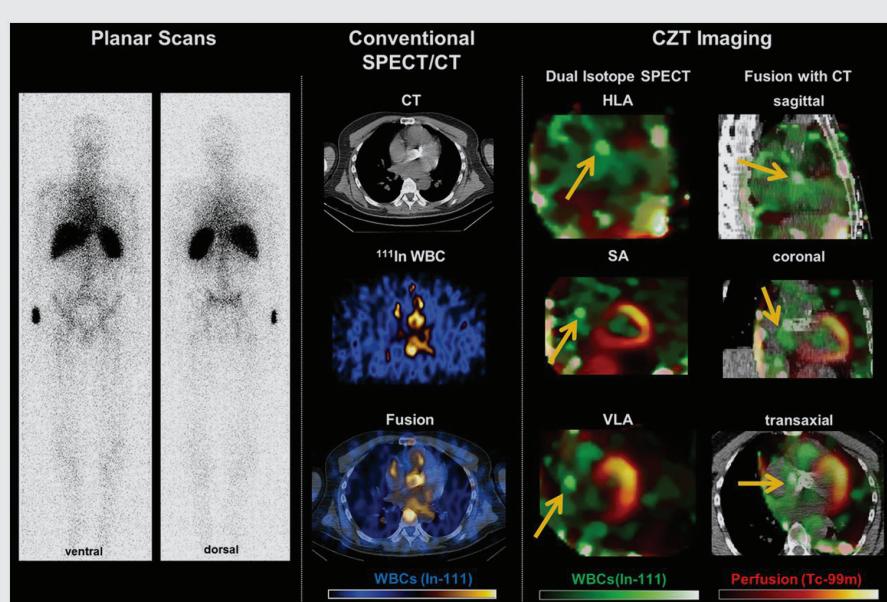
Evaluation of prosthetic valve endocarditis with nuclear imaging techniques. Representative images of a patient with suspected endocarditis of aortic valve prosthesis. From left to right, planar white blood cell scans show blood pool, with uncertainty about a valvular focus, whereas conventional SPECT/CT images suggest a potential hot spot in the region of the prosthetic valve, but with limited resolution. Dual isotope cadmium-zinc-telluride (CZT) images show reduced noise and a focal accumulation adjacent to the prosthetic valve suggesting the presence of endocarditis (arrows). During surgical aortic valve replacement, an abscess was identified under the right coronary artery ostium, matching the hot spot on the CZT scan and confirming the diagnosis of endocarditis.
